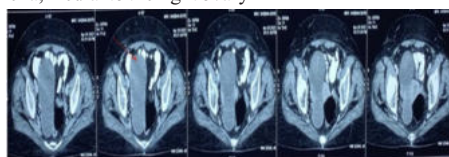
CT scan showing a 13.6 x 6 cm hypo-dense lesion with smooth wall enhancement noted in right adnexal region medial to right ovary.
